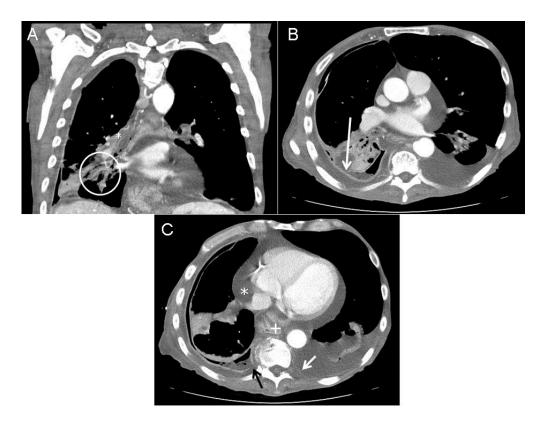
Selected views from the thoracic CT obtained 1 week after admission. Panel A: Architectural distortion (white circle) suggests necrotizing pneumonia. Note fluid within the bronchus intermedius (\*). Panel B: Defect in visceral pleura (arrow) with decompression of parenchymal necrosis into the pleural space. Note enhancement and thickening of both pleural layers. Panel C: Defect in parietal pleura (black arrow) with fluid extending into the extrapleural space. Pericardial effusion (\*), new left pleural effusion and left parietal pleura enhancement (white arrow) suggests spread of infection. Incidental hiatal hernia (+). A 71 year-old man with chronic obstructive pulmonary disease (COPD) presents to the emergency department complaining of dyspnea after recent admission for pneumonia. Chest CT shows a low density collection in the right lung suggesting necrosis (Figure 1). A CT obtained 1 week after admission (Figure 2) shows progression to empyema.
